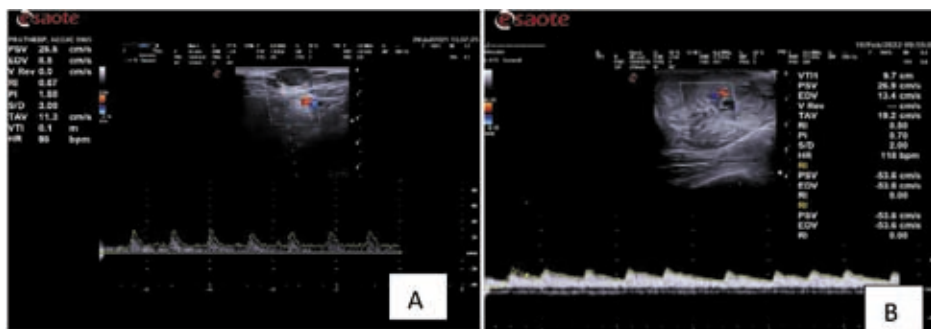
Spectral Doppler ultrasonographic image of mass with tumour neovascularisation and blood flow velocity waveforms in (A) A benign mammary neoplasm (B) A malignant mammary neoplasm
